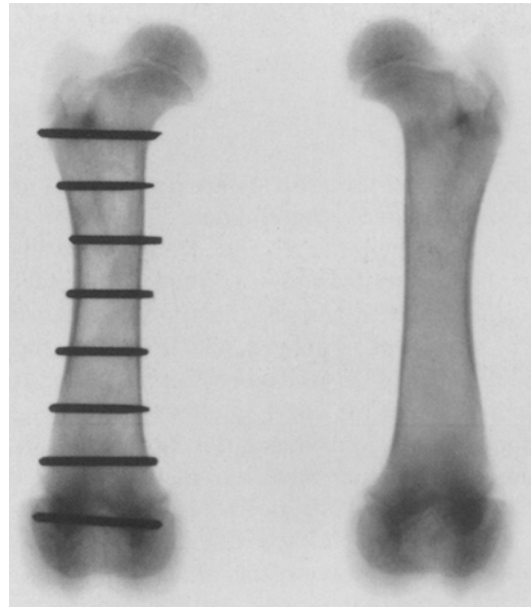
Radiograph taken 1 week after dislocation. All wires were still parallel
